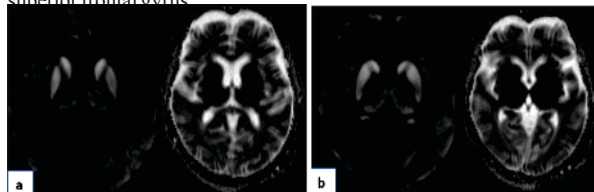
a) and b) DWI and ADC shows gyriform diffusion restriction involving bilateral basal ganglia and bilateral thalamus.
